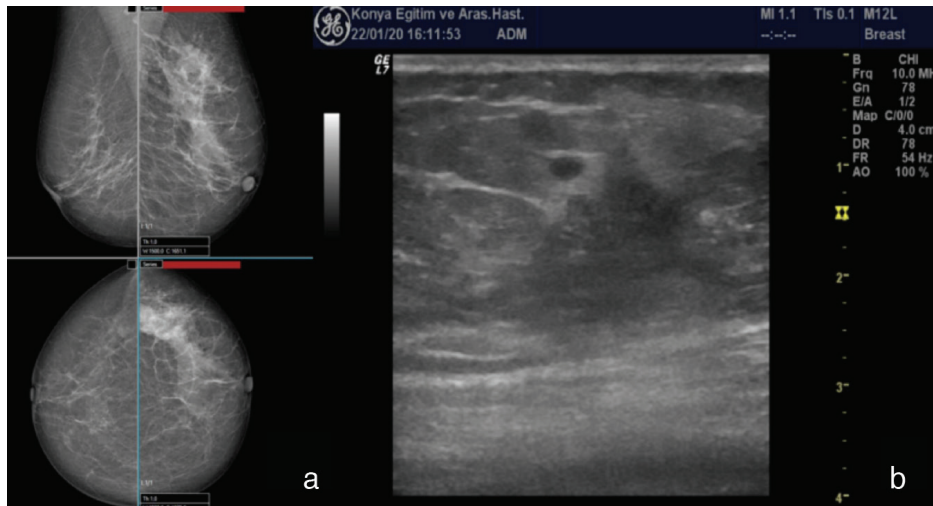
A 64-year-old woman presenting with pain in the left breast. (a) On the mammogram (MMG), there was a global asymmetric density increase in the upper left quadrant of the left breast. (b) On breast ultrasonography (USG), an irregular spiculated contoured mass lesion with a size of 22 x 16 mm was detected at a distance of 7 cm nipple, at 2 o'clock of the left breast. Imaging findings (MMG + USG) were reported as BI-RADS 5. The pathological result of the core biopsy taken from the defined lesion and USG was reported as a papillary neoplasm. The final pathological result of the excision was reported as encapsulated papillary carcinoma
